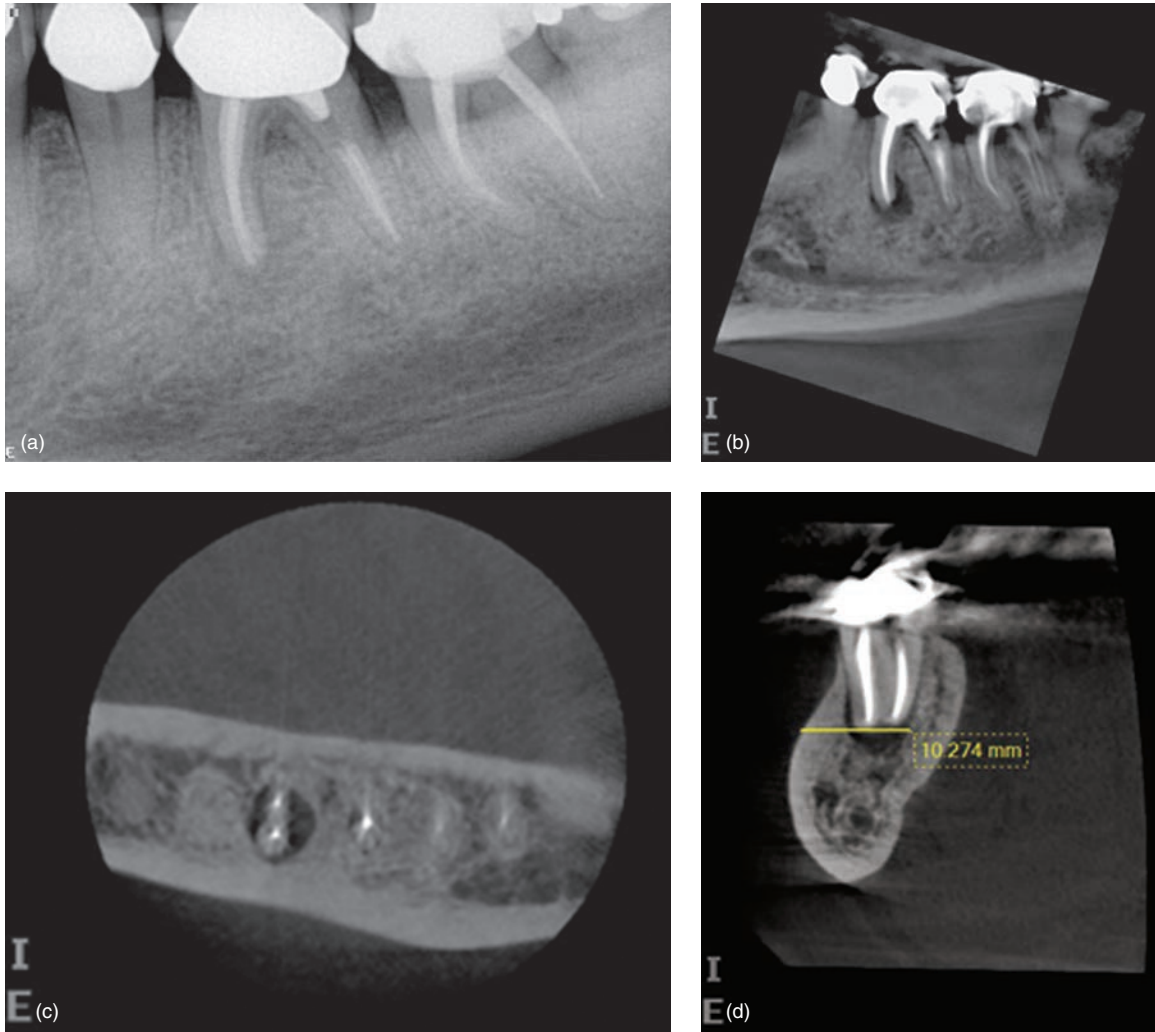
Previously treated mandibular first molar with apical periodontitis. (a) Periapical radiograph shows well-filled root canals and well-fitted crown restoration with a post in the distal canal. (b) Sagittal view showing large low-density area around the mesial root. (c) Axial view showing a well-defined, large low-density area limited to the mesial root. The buccal cortical bone is thick and intact. (d) Coronal view showing a thick buccal cortical bone and the location of the mesial root. Distance from the buccal cortical bone to the end of the mesial root exceeds the length of a Lindemann surgical bur and may limit full root resection. Therefore, non-surgical retreatment was chosen.
